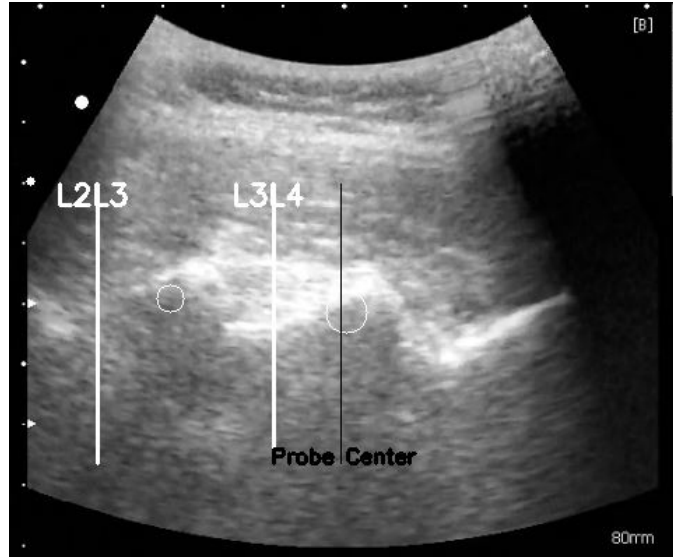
Spinous Level Identification Result on Original Ultrasound Image
